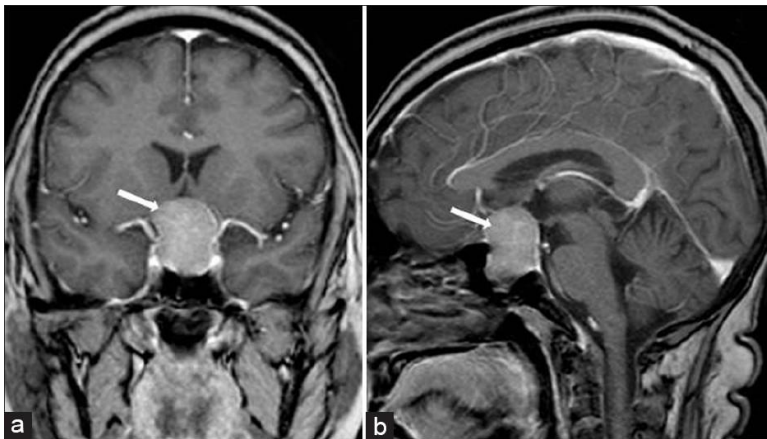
MRI image showing Pituitary adenomas, a. Coronal view, b. Sagittal view
